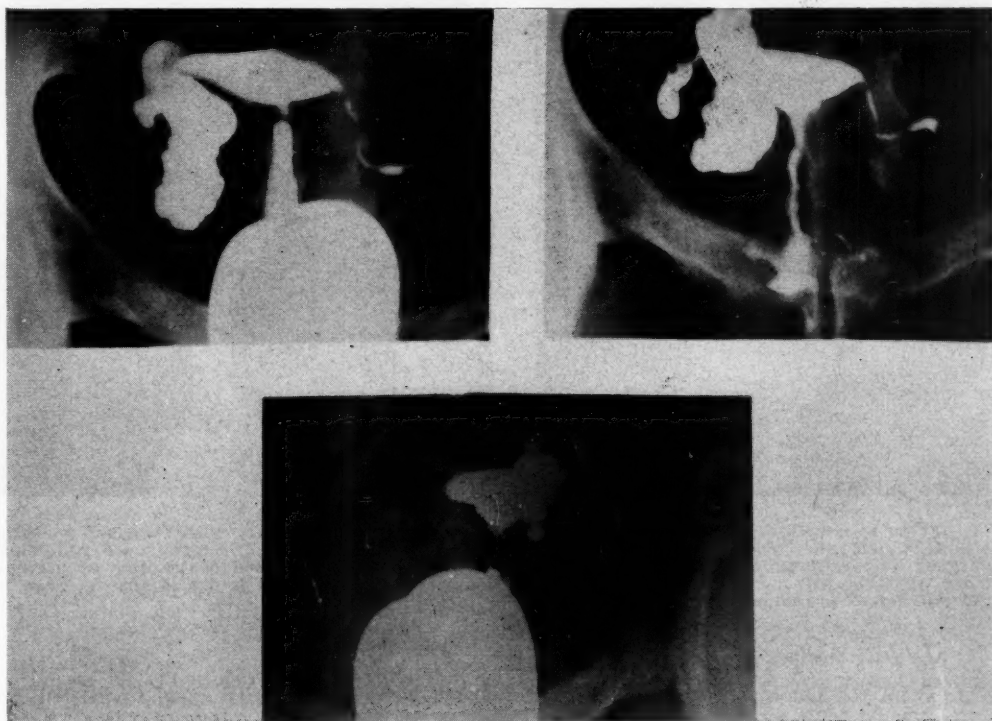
Next three x-ray pictures demonstrate postoperative result taken at three-month intervals following surgery. Patient became pregnant two months after last uterotubogram, eleven months after surgery.
